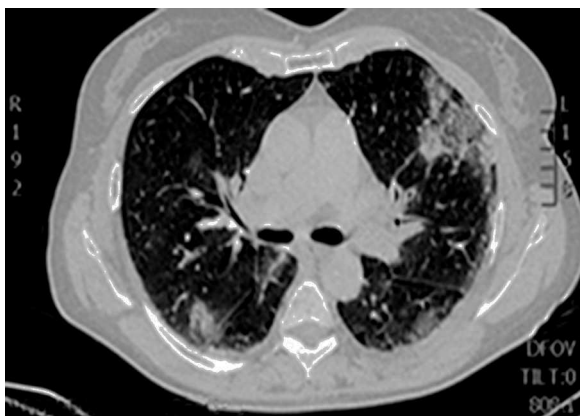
Computed tomography of the thorax showing bilateral lung infiltrates.
